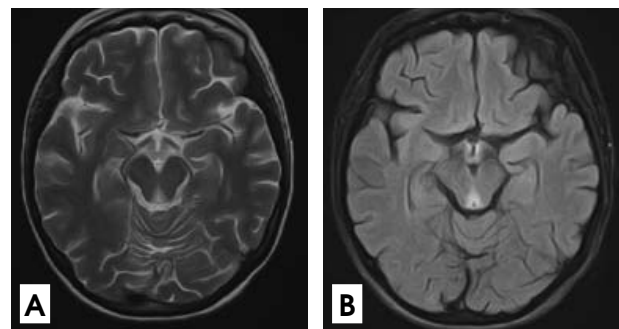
Symmetrical high intensity in periaqueductal areas on non-enhancing T2 (A), and fluid-attenuated inversion recovery (FLAIR) (B) sequence images
